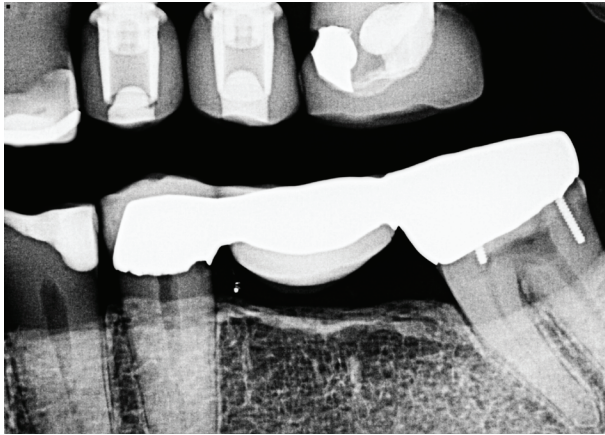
Preoperative bitewing with caries on abutment teeth #18 and #20
